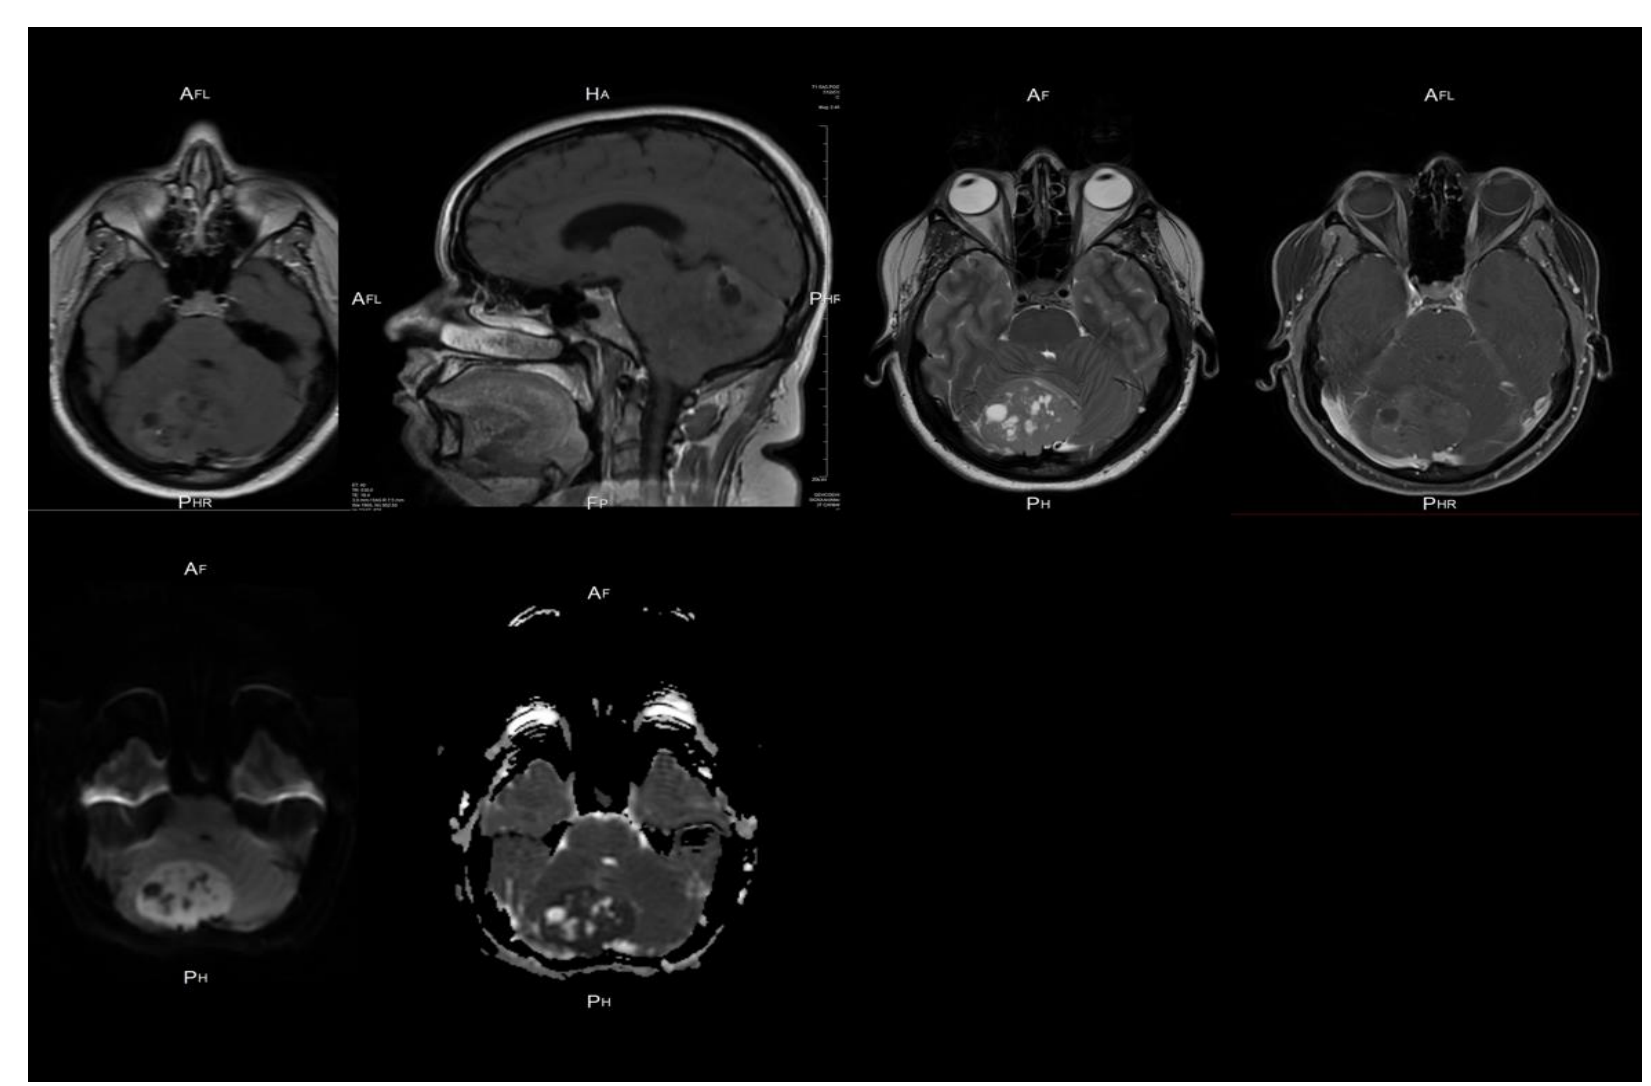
Top row: T1 post contrast without fat saturation axial - T1 post contrast without fat saturation sagittal - T2 axial - T1 post contrast with fat saturation axial Bottom row: Diffusion weighted imaging (DWI; abnormal is bright) - Apparent Diffusion Coefficient Map (ADC 10<sup>-6</sup> mm<sup>2</sup>/s; abnormal is dark)
